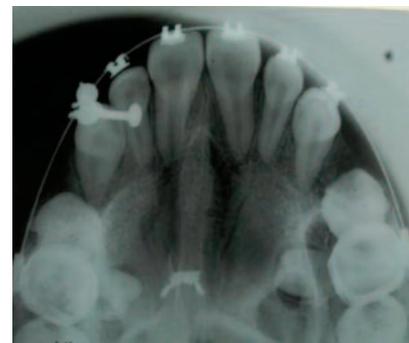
Maxillary Occlusal Radiograph bilateral showing the impacted premolar.
